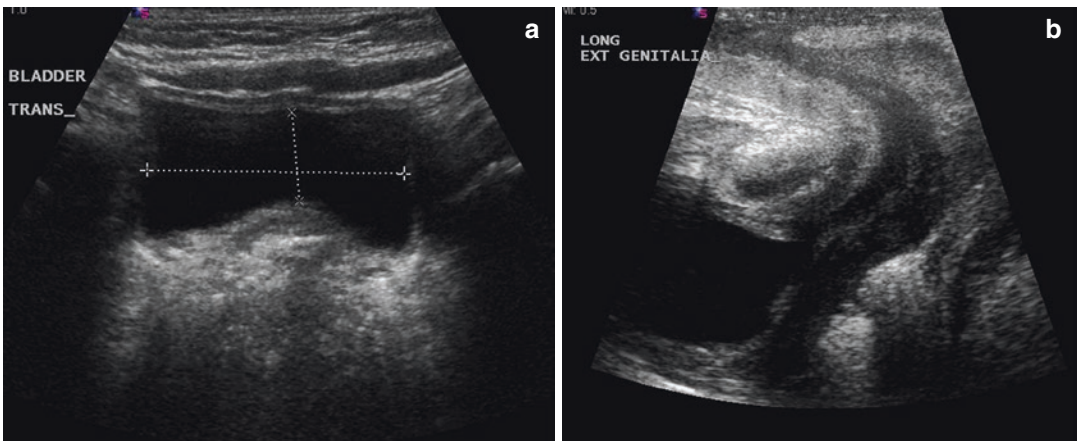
Male Pelvic Ultrasound (a) Transverse view—note bladder and rectum with no evidence for a uterus. (b) Perineal view demonstrates a long urethra. Note pubic symphysis
